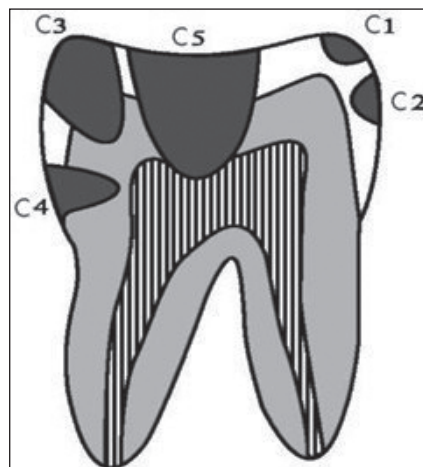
X-ray classification of carious defect depth according to J. Espelid, B. Tveit (1986): C₁ – dental cavity located only within half the width of enamel; C₂ – caries that damages more than half the thickness of enamel but does not reach amelodentinal junction; C₃ – caries of enamel and dentine, in which defect takes at least half the layer of hard tooth tissues to the tooth cavity; C₄ – defect that takes more than half the thickness of dentine but is not connected to the tooth cavity; C₅ – carious defect that can reach tooth cavity.
